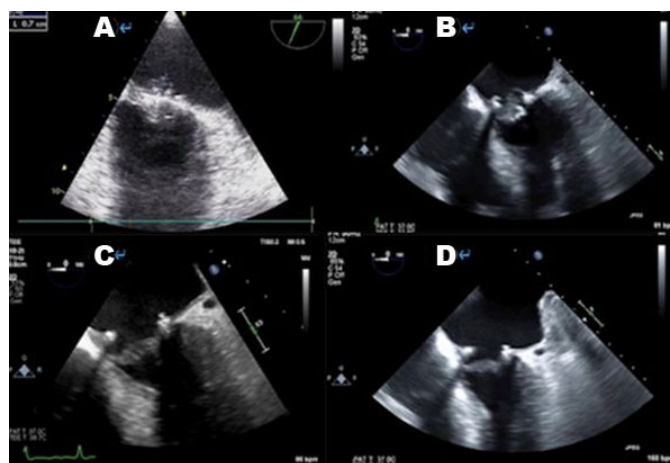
Transesophageal echocardiography images on (A) day 1, (B) day 11, (C) day 24, and (D) day 47.
